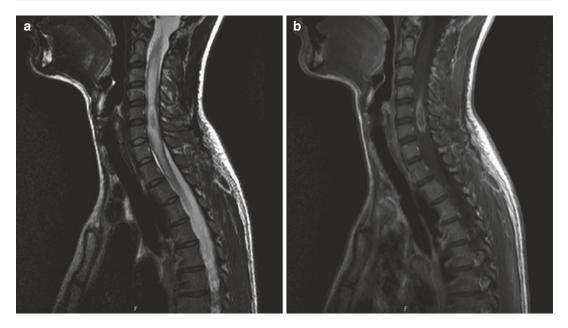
Initial MRI scan. The MRI scan shows an intramedullary astrocytoma at C5/6. Sagittal T2 (a) and contrast T1 (b)
